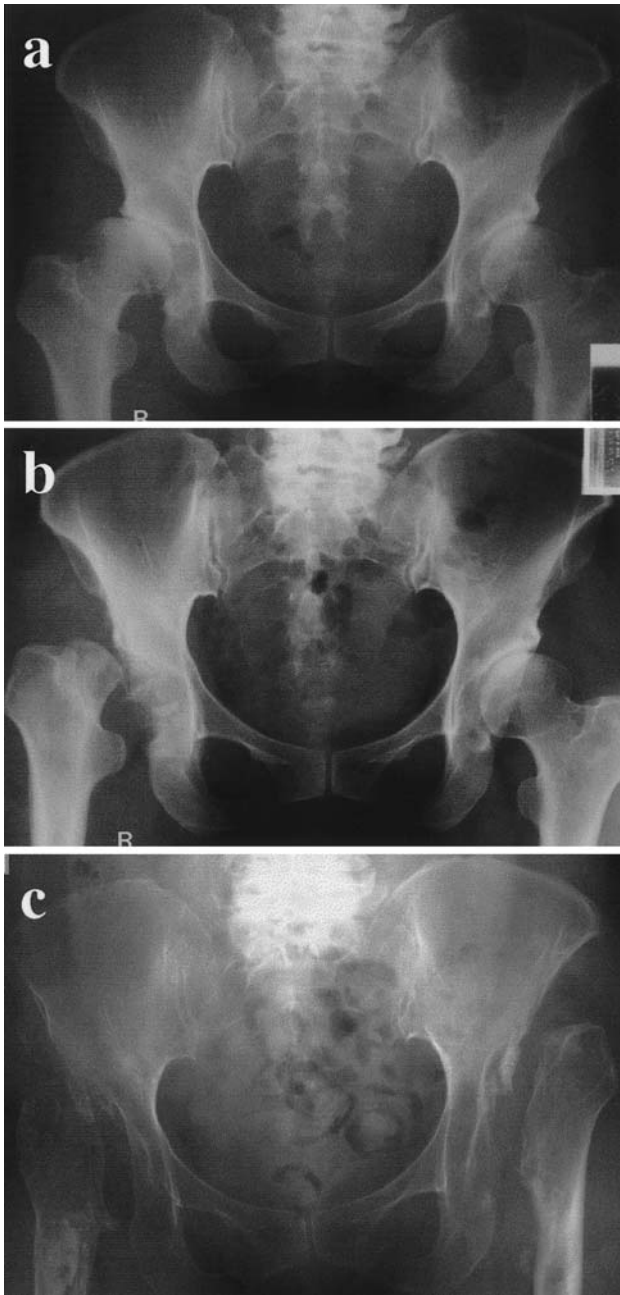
Sequential radiographs of the hip joints of a 43-year-old woman with neuropathic arthropathy. a In April 1987 the acetabula were dysplastic with osteosclerotic changes in load-bearing areas. Linear fractures and fragmentation on the right hip joint were seen. b One month later, the right femoral neck was absorbed with hip dislocation. c Fifteen years later, upward migration of the femoral necks had increased, and the left femoral head was absorbed
